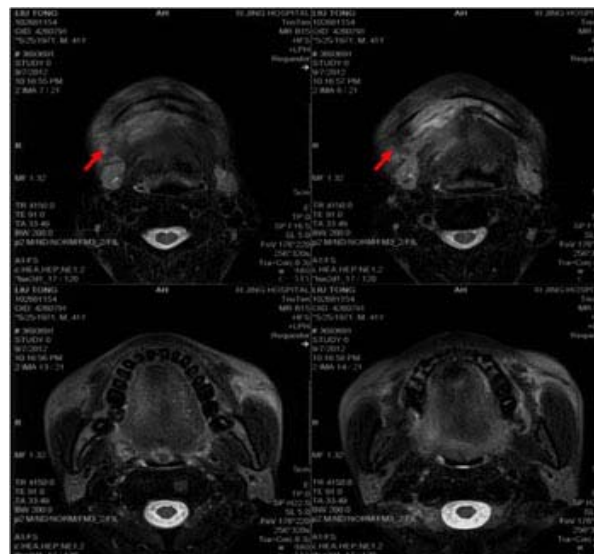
CT picture of HNSCC.
